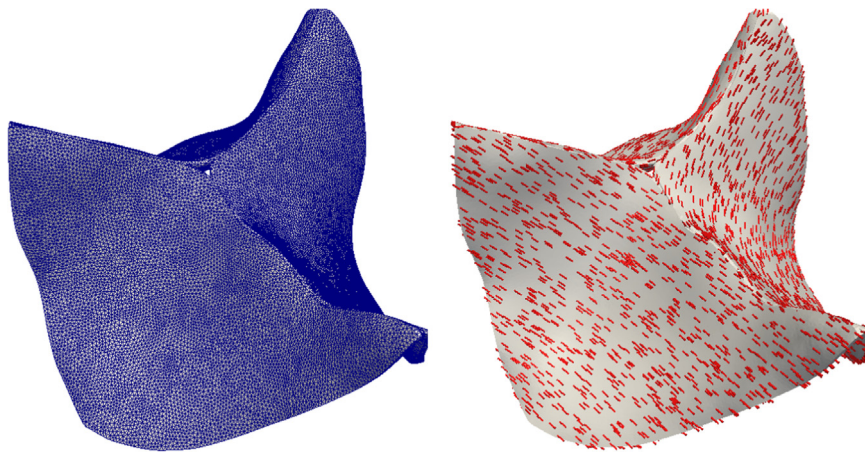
Computational mesh (mesh size 0.25 mm) of the aortic valve (left) and assigned circumferential fiber family (right). The aortic valve geometry was created from computed tomography data from a 71-year-old male individual with no known valve disease.
